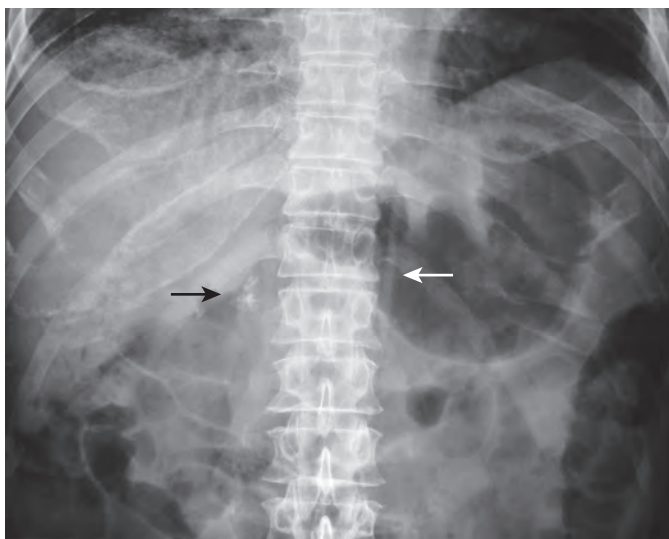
Diaphragmatic crus and calcified adrenal gland. Supine abdominal radiograph shows a calcified right adrenal gland (*black arrow*) and left diaphragmatic crus (*white arrow*). The right diaphragmatic crus is partially visualized just medial to the calcified right adrenal gland.
